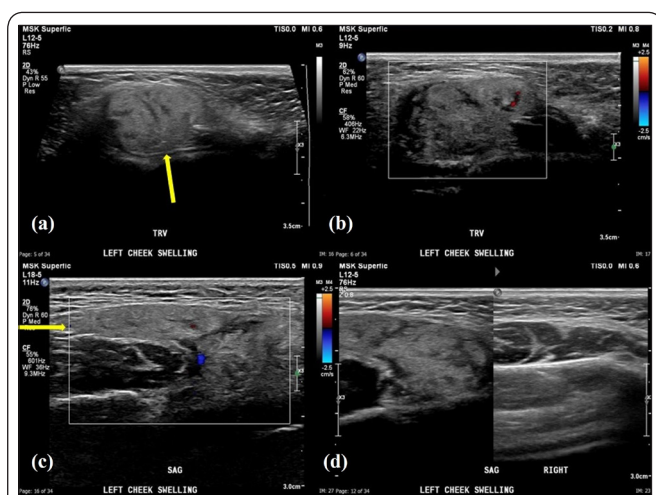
Bedside ultrasound of the left cheek, focused on the location of swelling. (a) Transverse imaging reveals a complex, heterogeneous structure adjacent to the left parotid gland which exhibits cobblestoning (yellow arrow). (b) Doppler imaging in the transverse plane of this complex structure reveals no significant internal vascularity. (c) Redemonstration of the complex, heterogeneous structure in the sagittal plane (yellow arrow). (d) Comparison of the left and right cheeks in the area of clinical concern confirms the left-sided asymmetry.
